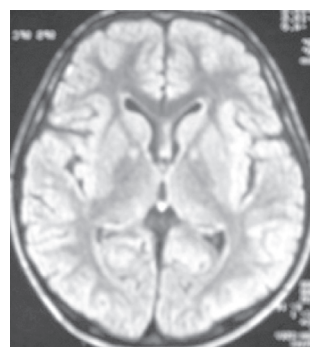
Axial T₂ magnetic resonance image, revealing the classic “eye of the tiger” sign characteristic of pantothenate kinase-associated neurodegeneration.
